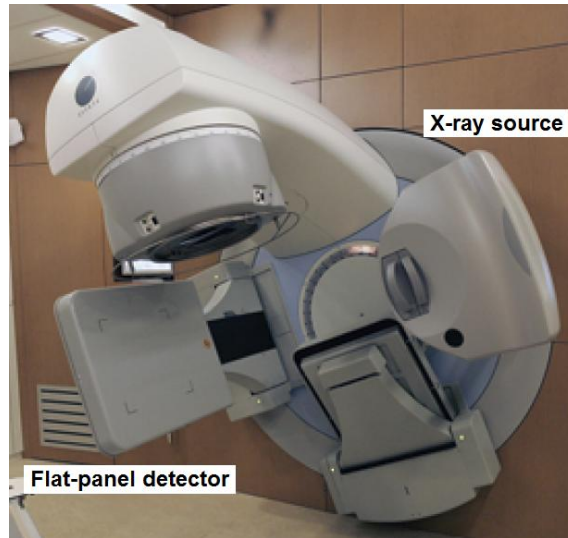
Kilovoltage cone-beam CT scanner mounted on a linear accelerator, consisting of an X-ray source opposite to a flat-panel detector.
